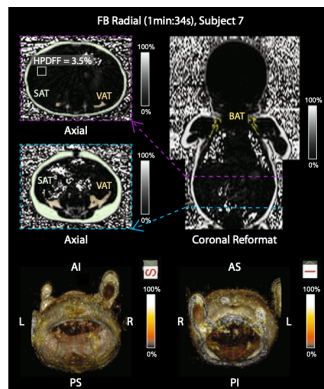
Radial free-breathing MRI was performed on infants. Visceral (VAT), subcutaneous (SAT) and brown adipose tissue (BAT) was measured on the PDFF maps.
